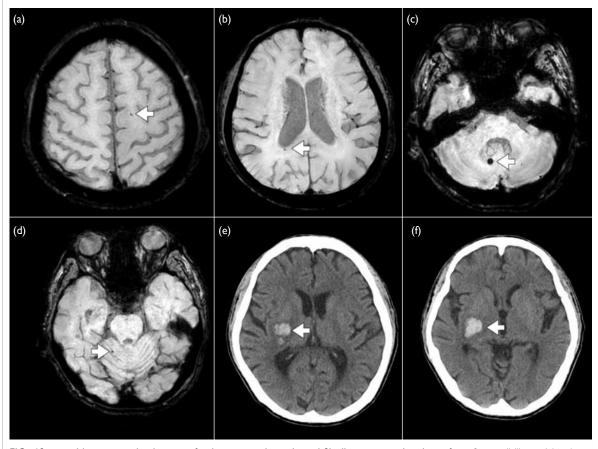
year-old patient with a history of ischaemic stroke and atrial fibrillation treated with warfarin. Susceptibility-weighted magnetic resonance imaging of the brain at baseline showing a total of 5 cerebral microbleeds over the (a) left frontal lobe, (b) right parietal lobe, and (c, d) right cerebellum. (e, f) Computed tomography of the brain showing intracerebral haemorrhage over the right putaminal region after the patient had sudden onset of left leg weakness 4 months after recruitment.
